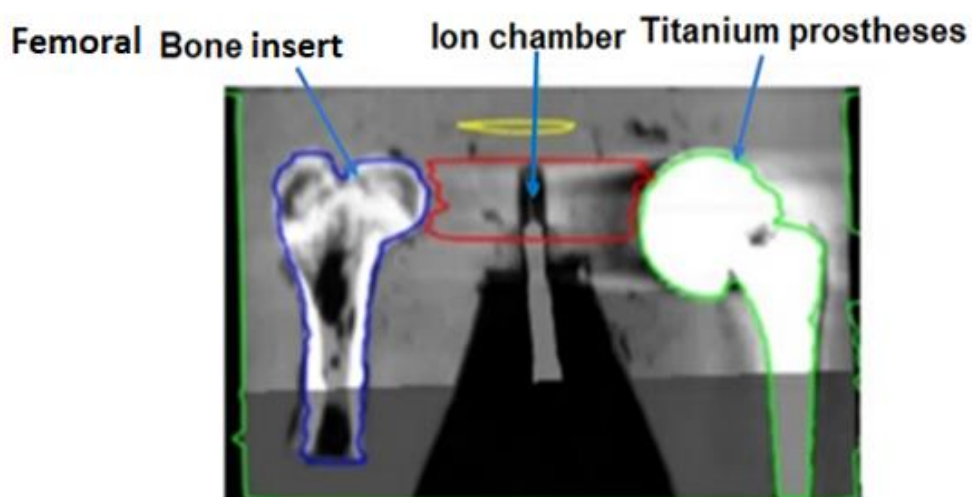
14: Registration of CBCT and planning CT image position with the ionization chamber inside the prostate cavity (in red) (Eclipse treatment planning system (TPS) (Varian MedicalSystems, Palo Alto, CA)).
